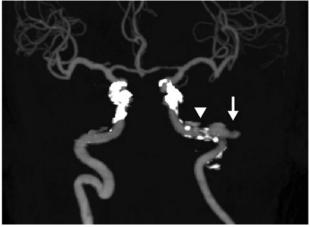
(a) Coronal contrast-enhanced computed tomography (CT) scan and (b) CT angiography image, showing a left-sided petrous internal carotid artery (ICA) aneurysm (arrows), with ICA stenosis at the distal portion of the aneurysm (arrowhead).
